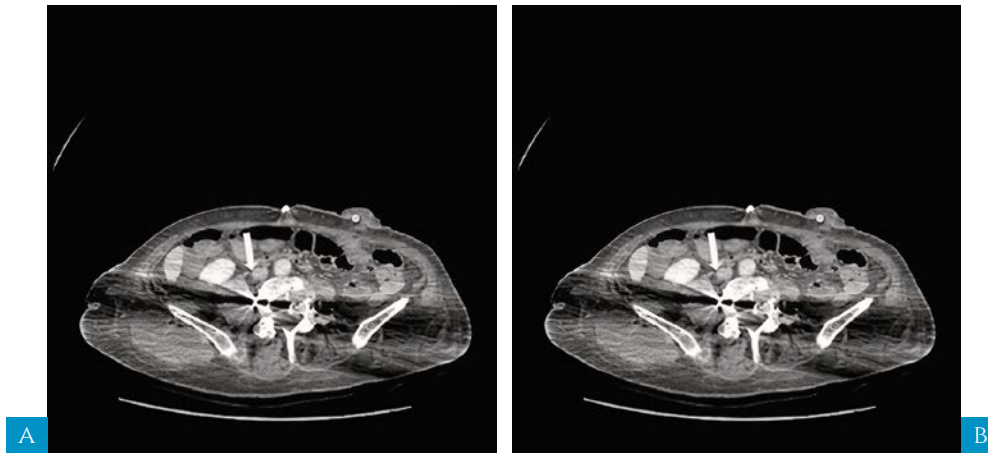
a, b: post contrast CT performed 2 weeks later in which the embolization material is seen. The collections are liquefying due to central necrosis and there is also peripheral enhancement, findings that are associated with abscesses that were drained with CT guided percutaneous drainage.
